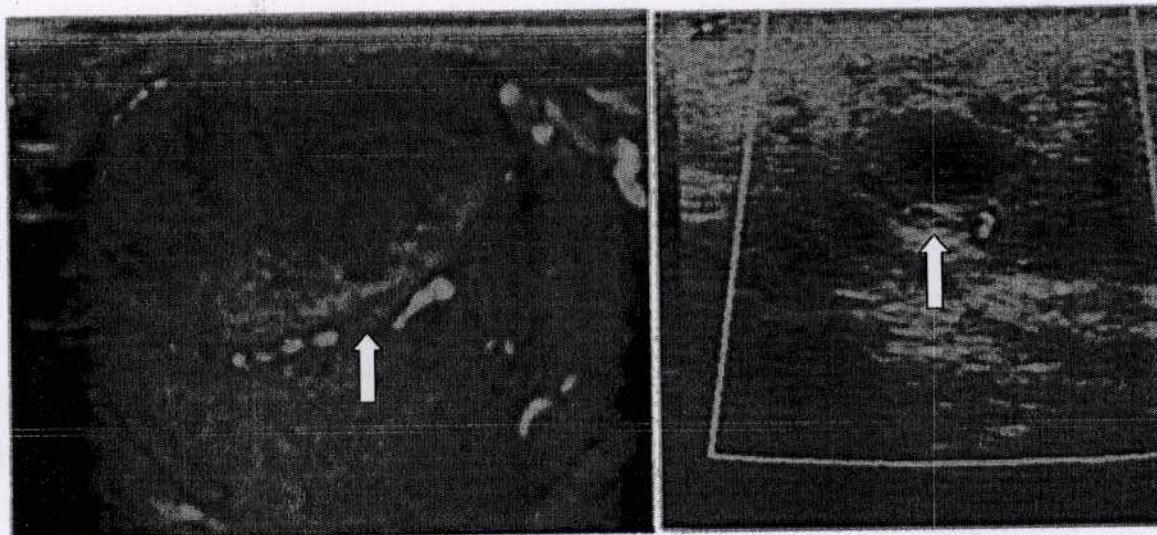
A) Intra testicular abscess in a 30 year-old man. Color Doppler US scan shows flow non homogenous avascular lesion in anterior aspect of left testis. B) Cystadenoma of epididymis in 31 year old man of VHL. Color Doppler US scan shows No flow within the well-defined cystic structure which is antero-lateral to the testis.
